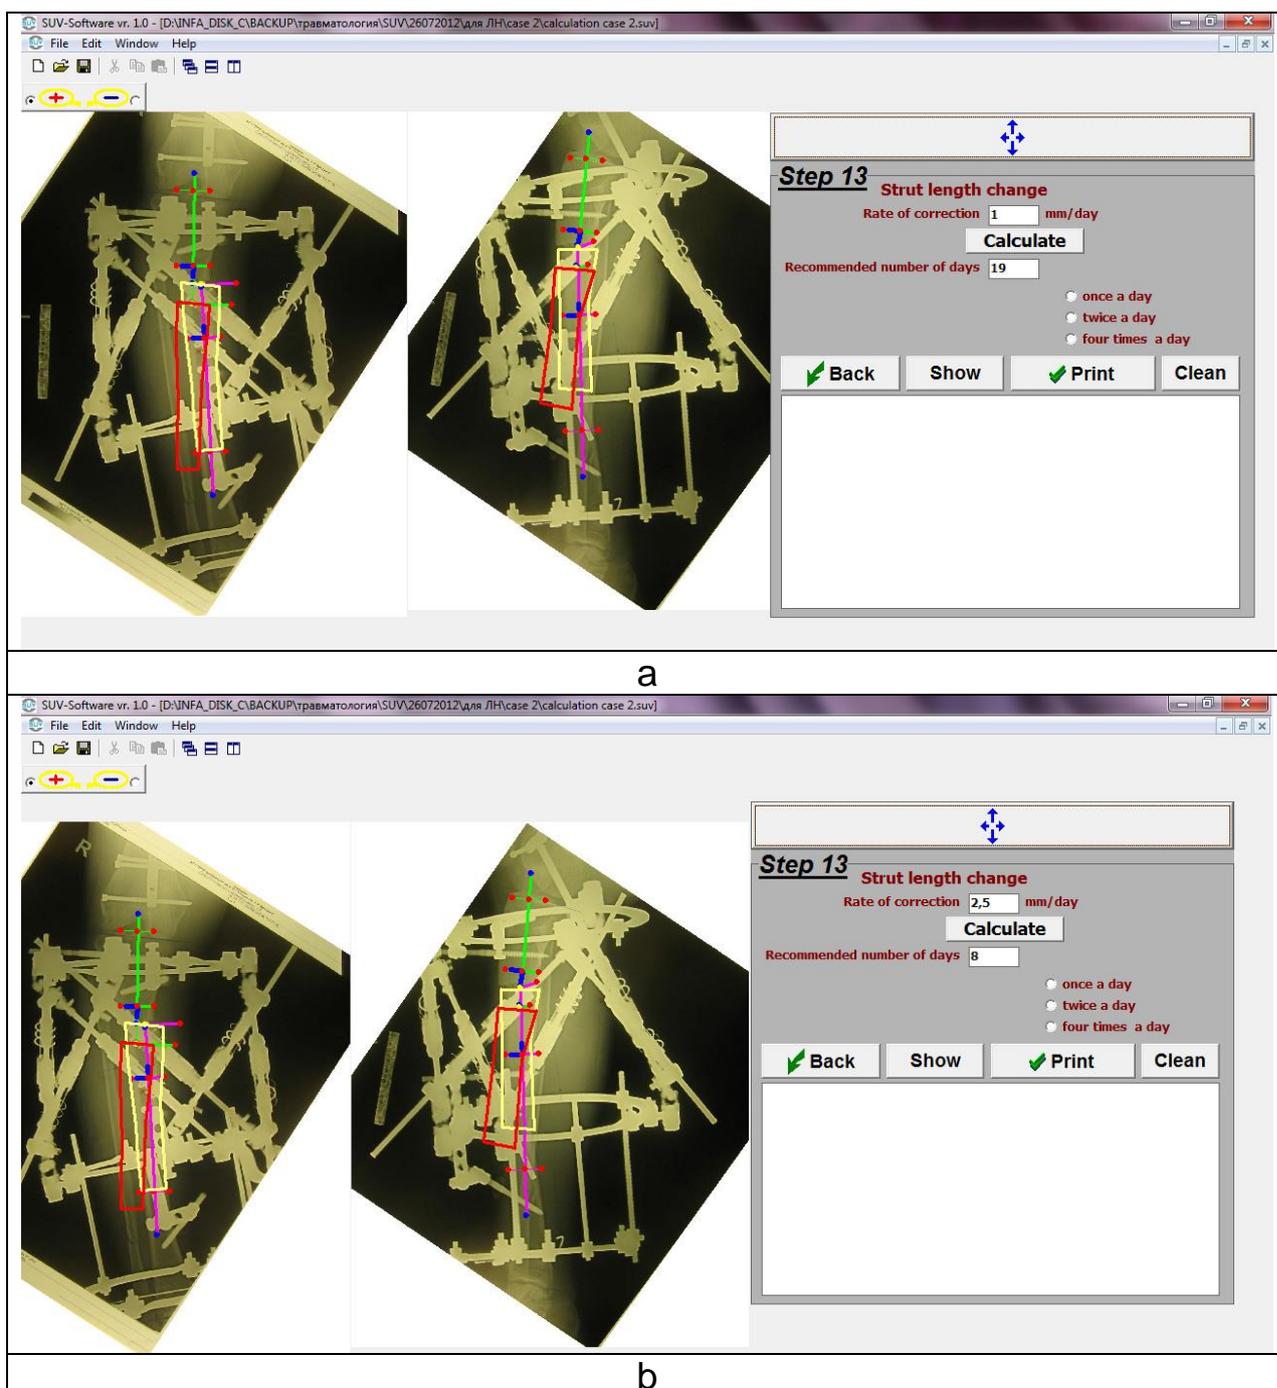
Ortho-SUV program window in Step 13: identification numbers of days needed for deformity correction. a - software has calculated recommended number of days for deformity correction at rate 1 mm/day - 19 days. The user can ignore this value. To do this just remove it and enter number of days required. b - there is another possibility to change number of days for deformity correction. For this purpose it is necessary to change value in the field "Rate of correction" for necessary one (for example, 2.5 mm/day) and again (do not forget it!) press the button "Calculate". The program has calculated, that at new rate 8 days are necessary for deformity correction
